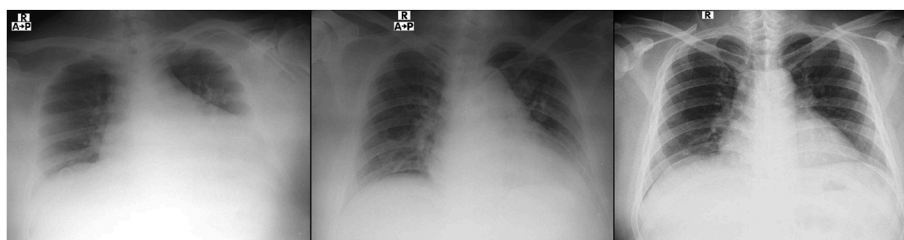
Thorax radiography of patient on 2nd, 3rd, and 21st of May (hospital day 5).
